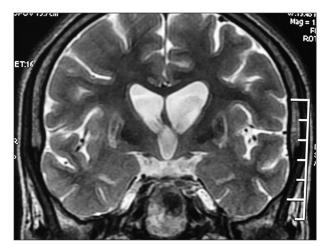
Coronal T2-weighted image showing hyperintense lesions in bilateral basal ganglia
